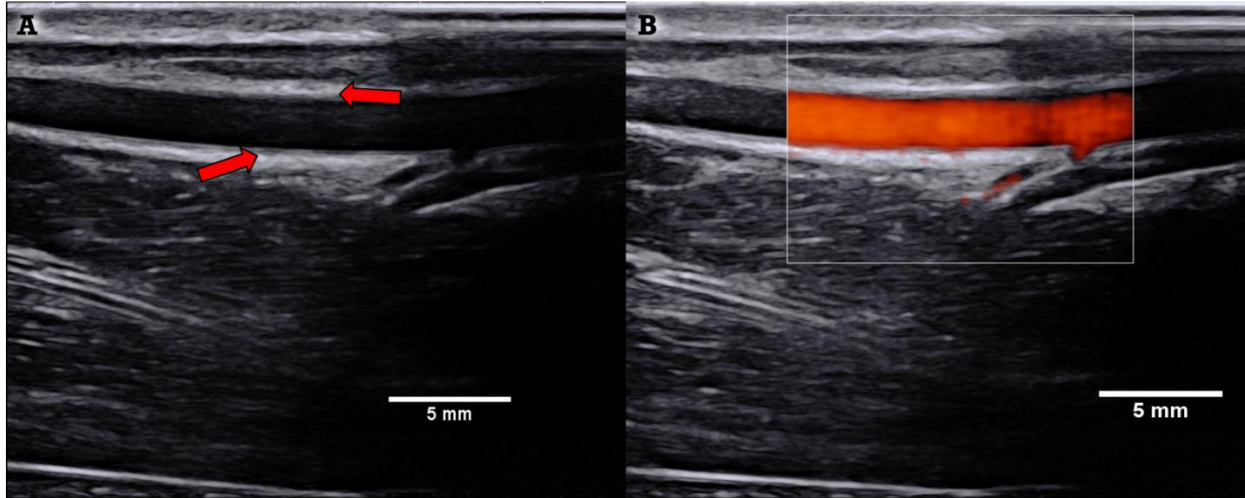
B-Mode Ultrasound Image at 20-6 MHz range, representing the various layers of tissue within an arm, with red arrows marking the vein walls (A). Doppler image accurately represents the blood flow inside the vein (B).
